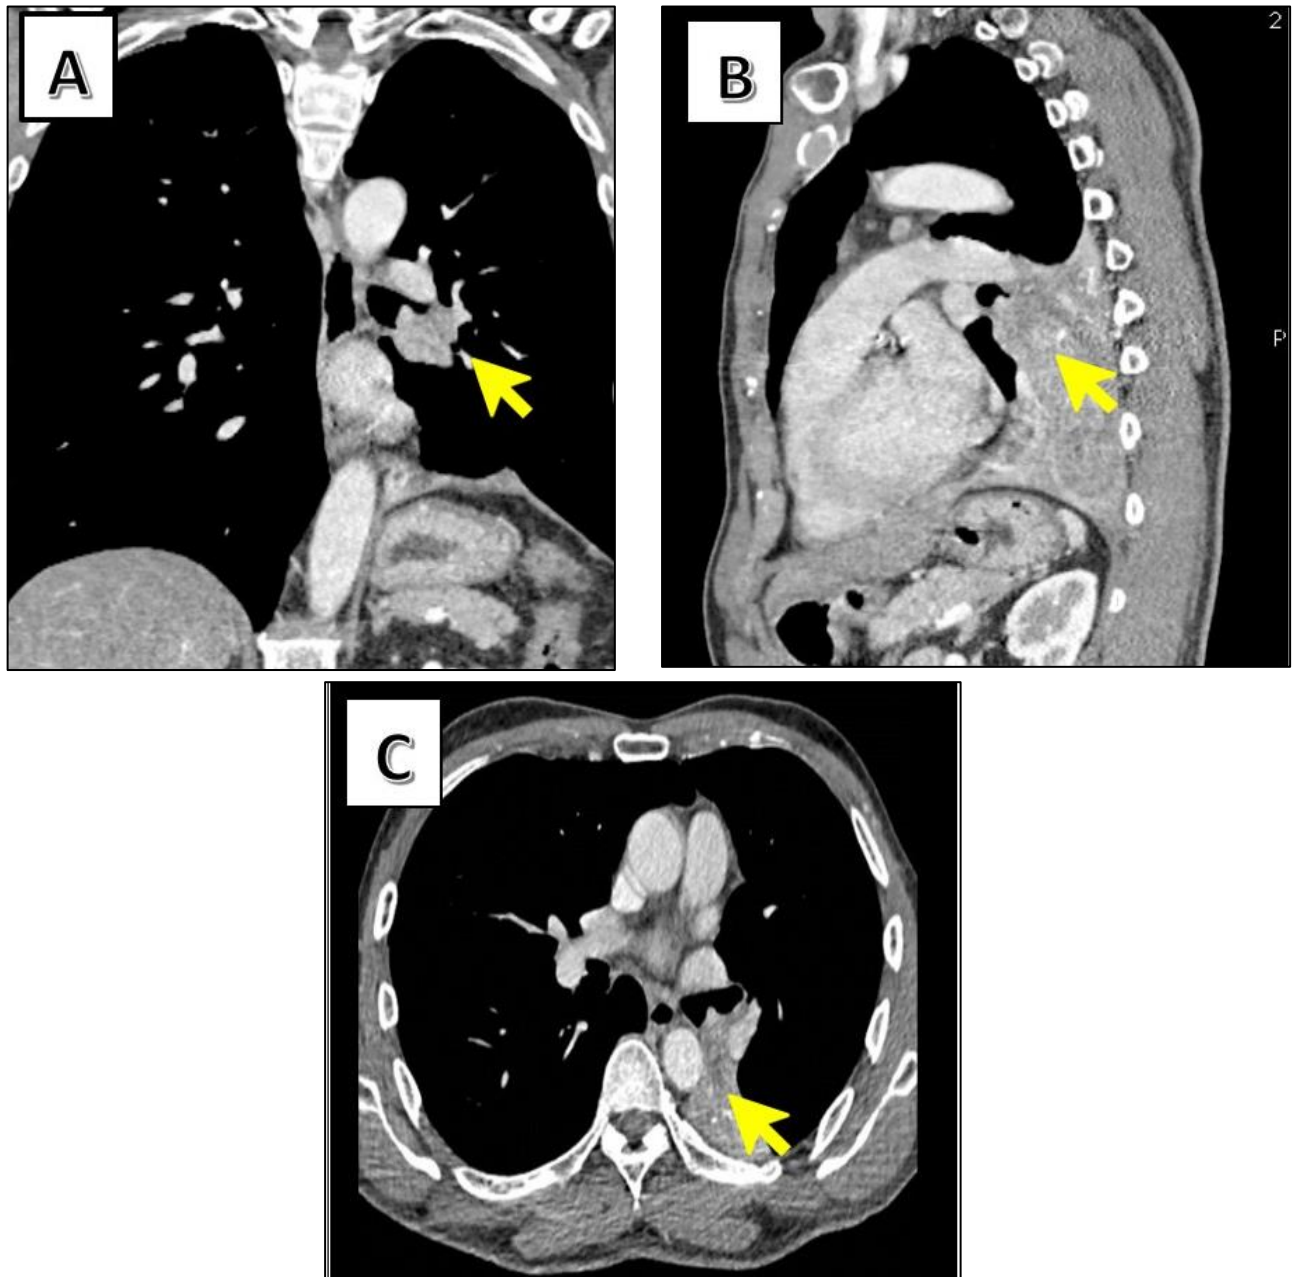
Selected CT thorax on coronal view (A), sagittal view (B) and axial view (C) demonstrating an enhancing mass obliterating the left lower lobe bronchus causing collapse of the left lower lobe with mediastinal lymphadenopathy suggestive of malignancy.
